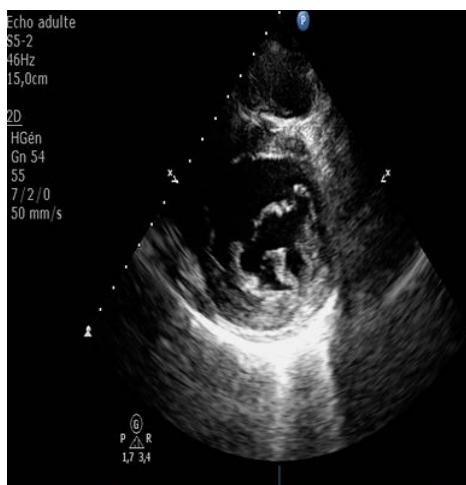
Parasternal long axis view showing a cleft of posterior leaflet.
